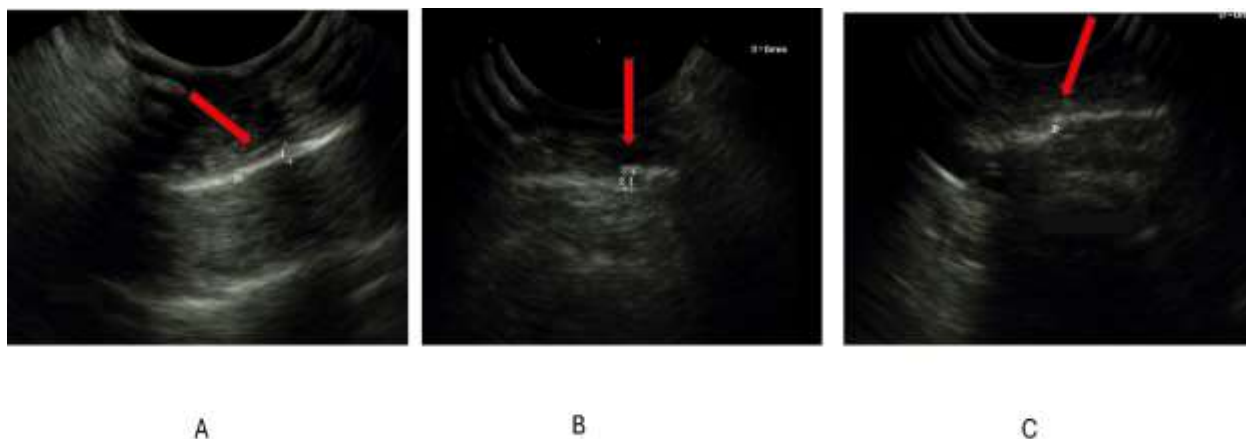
Ultrasonography: Tendon healing comparison at trial end. Best to poor healing in group C, B and A respectively
